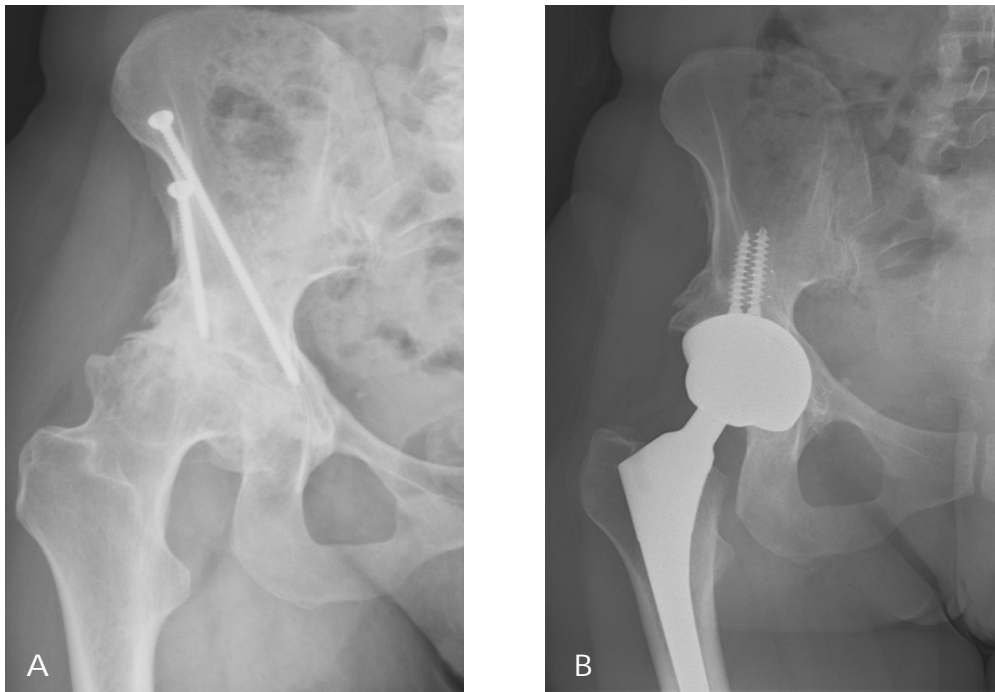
Section of a weight-bearing AP pelvic radiographs. A. Preoperatively before THA, 6½ years after PAO. B. 4½ years after THA.
